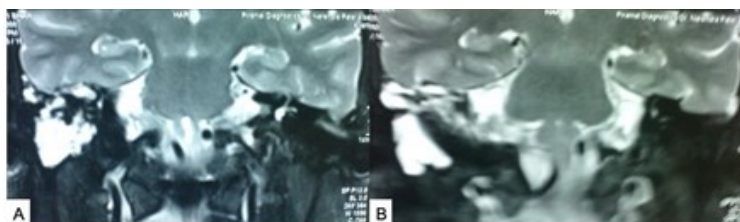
(A,B) MRI of brain and skull base (coronal T2W images) showing spontaneous CSF fistula (otorrhea) passing through right mastoid air sinus and middle ear cavity (tegmen tympani dehiscence). Source: Figure by authors.
